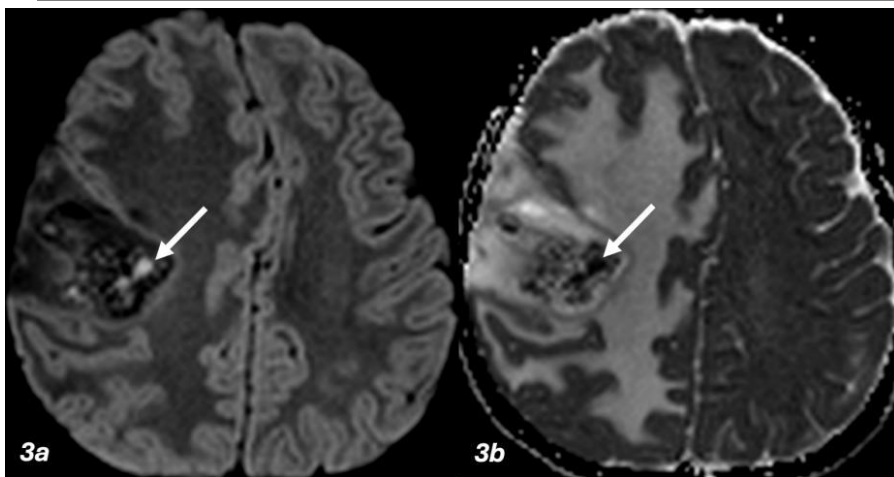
MRI brain DWI/ADC¹ mapping of the lesions show central restricted diffusion (white arrow); central hyperintensity on DWI (3a) and hypointensity on ADC (3b). ¹DWI/ ADC; diffusion weighted imaging/apparent diffusion coefficient.
